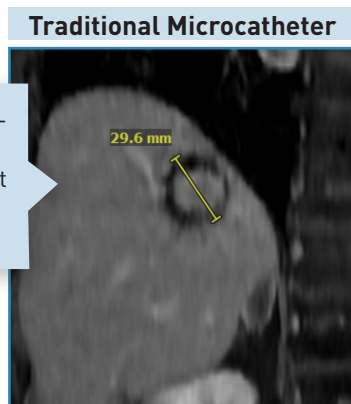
MAA SPECT via traditional microcatheter (left) and Y90 SPECT via TriNav LV (right) shows significantly better tumor targeting using the TriNav LV.
